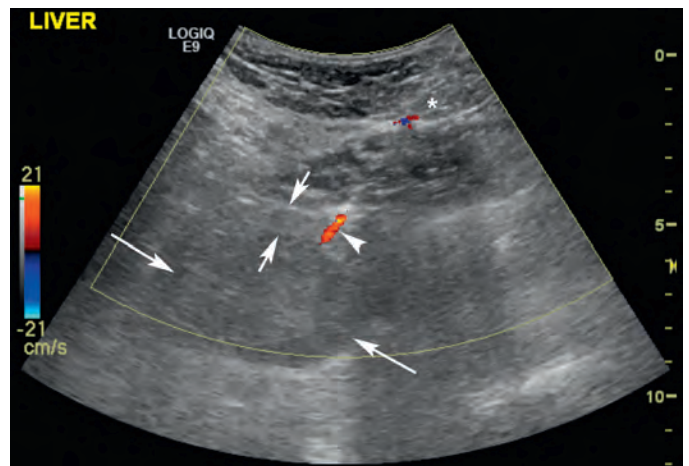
Ultrasonogram of a 51-year-old man with melanoma. Color ultrasound of the liver following percutaneous needle biopsy of a hypoechoic hepatic mass (long arrows). The needle transgressed approximately 1 cm of normal hepatic parenchyma (short arrows). As the needle (asterisk) was removed from the liver, a tract of blood was evident along the needle path (arrowhead) toward the liver capsule. There was, however, no evidence of subcapsular accumulation of blood, and the track resolved within 30 to 60 seconds.
